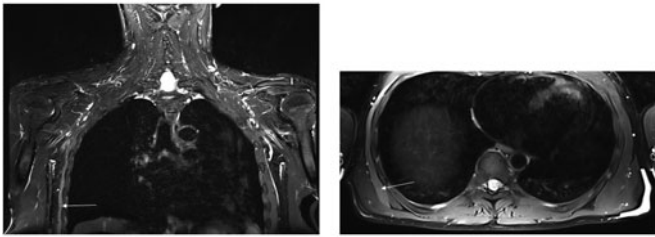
Scapular MRI of case n°4: coronal section, T2 Dixon water sequence (A), and axial section, T2 Dixon water sequence (B) showing hyper signal and amyotrophy of right serratus anterior muscle (white arrow).
